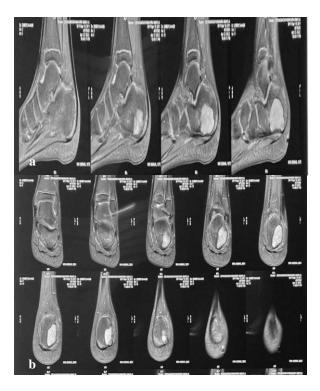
(a and b): MRI showing CMF lesion in calcaneum.
